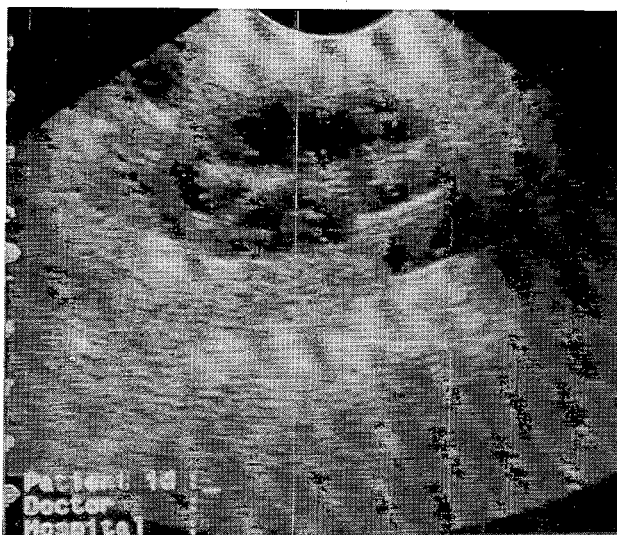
Ultrasonographic appearance of a mass with increased medullary echogenicity and reduced clarity of the corticomedullary junction.
